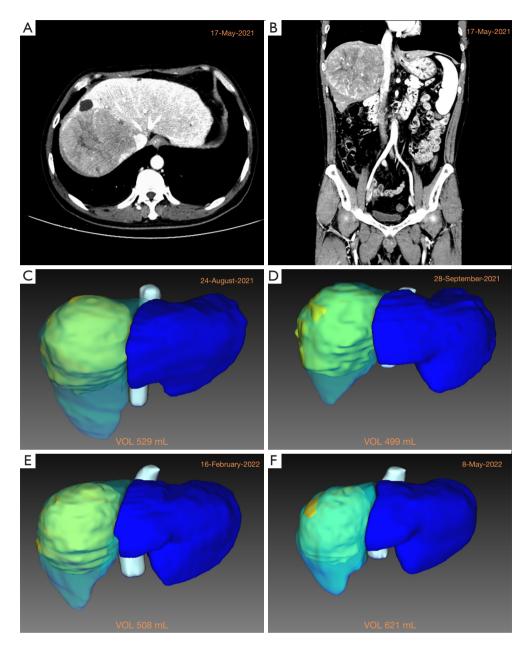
Changes in the patient's liver volume over the course of treatment. (A,B) Contrast-enhanced abdominal computed tomography showing a hypodense mass in the right lobe of the liver with a diameter of 14 cm, and invasion of the middle hepatic vein and inferior vena cava. (C-F) Changes in the volume of the left lobe of the liver during treatment. VOL, volume of the left liver.
